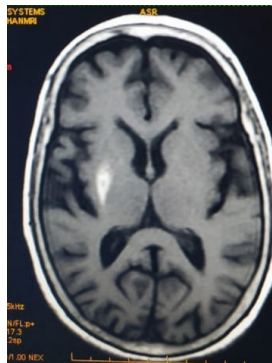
MRI image of the patient showing T1 hyperintensity in right lentiform nucleus.
